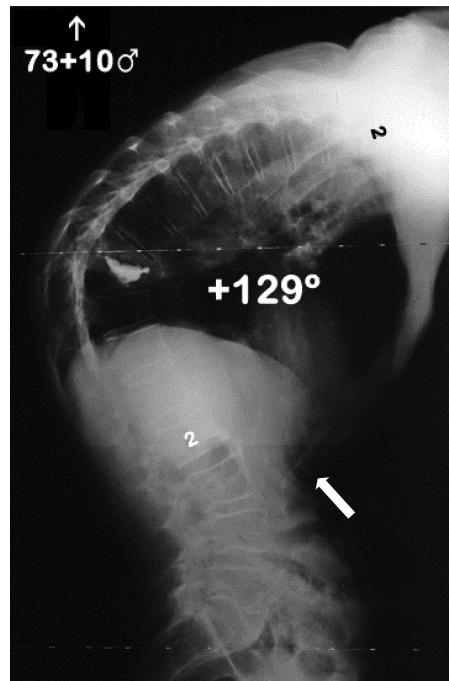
Standing lateral radiograph showing thoracolumbar kyphosis of 129° due to collapse of the T9 and T10 vertebrae and the cement from the vertebroplasty. Arrow points to the tip of his sternum protruding into his abdomen in close proximity to his anterior vertebral column.
